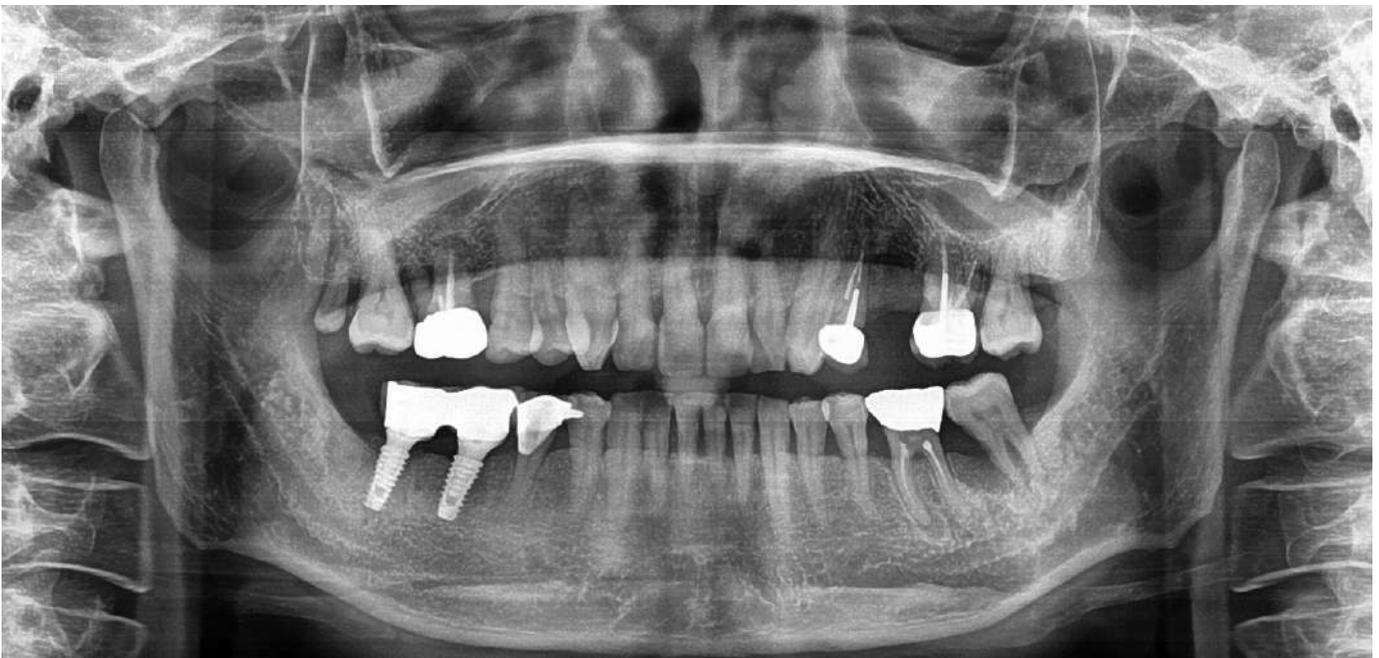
Post-operative panoramic X-ray
